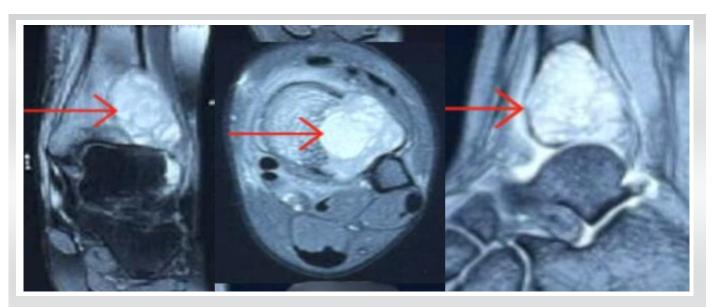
Magnetic resonance imaging. T2 proton weighted imaging of the left ankle showed a 4 x 2.5 x 3.1 cm lesion arising in the epiphysio-metaphyseal region of the distal tibia involving the articular surface with multiple.
